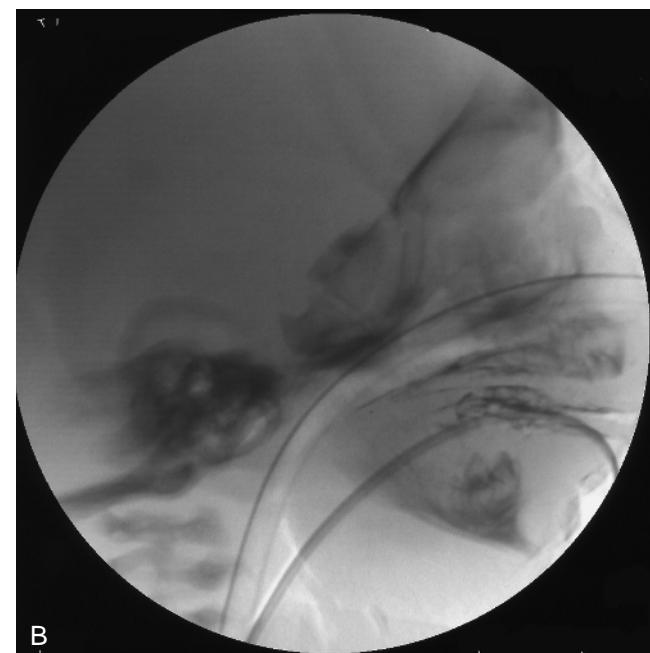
(A) Micrognathia in a 1-month-old girl. The chin is noticeably recessive. (B) The radiograph shows the extent of the development of the dentition at birth. When the patient was 1 year old, the micrognathia was less noticeable.
